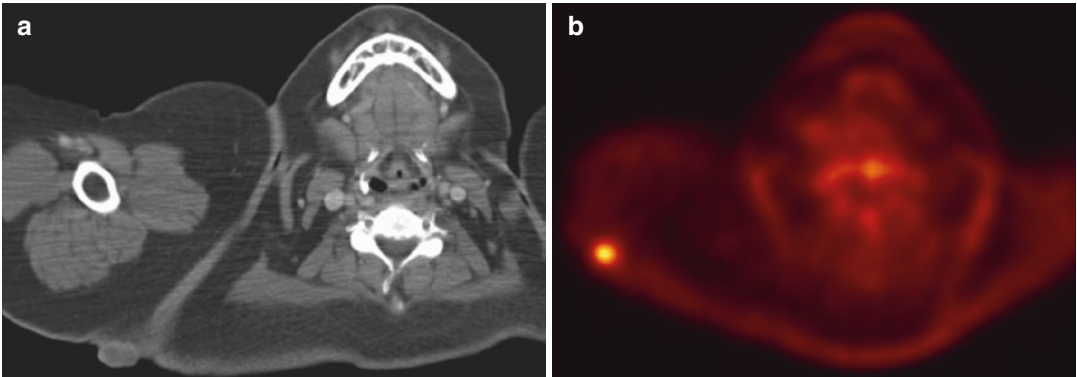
Cutaneous leiomyosarcoma. Postcontrast CT scan (a) shows a small exophytic skin nodule from the posterior shoulder, with peripheral rim enhancement. PET (b) shows the lesion to be hypermetabolic
